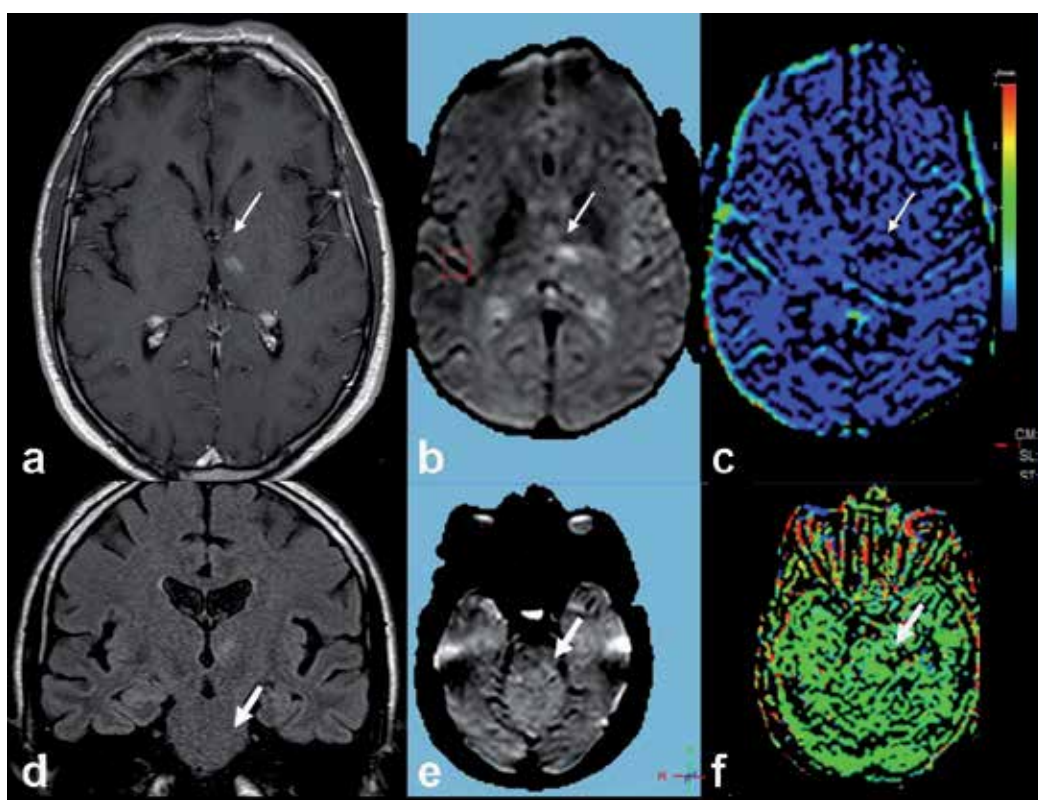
Despite the presence of dullness and flight of ideas in the case presented with behavior disorder that developed recently, systemic and cranial screening is required because of concurrent attacks and sweating. On the T1W-C⁺ axial section (a), thalamic focus that uptakes contrast agent (arrow) has displayed T2-shine through effect on the perfusion sequence (b, arrow), and presented completely as non-perfused on the rCBV map (c, arrow). The same focus is visualized on the coronal FLAIR sequence (d). Although the pons is seen normal on this sequence (d, arrow), it is seen as a suspicious field on the basic perfusion image (e, arrow) and again as non-perfused on the rCBF map (f, arrow). Left thalamic subacute infarction.
